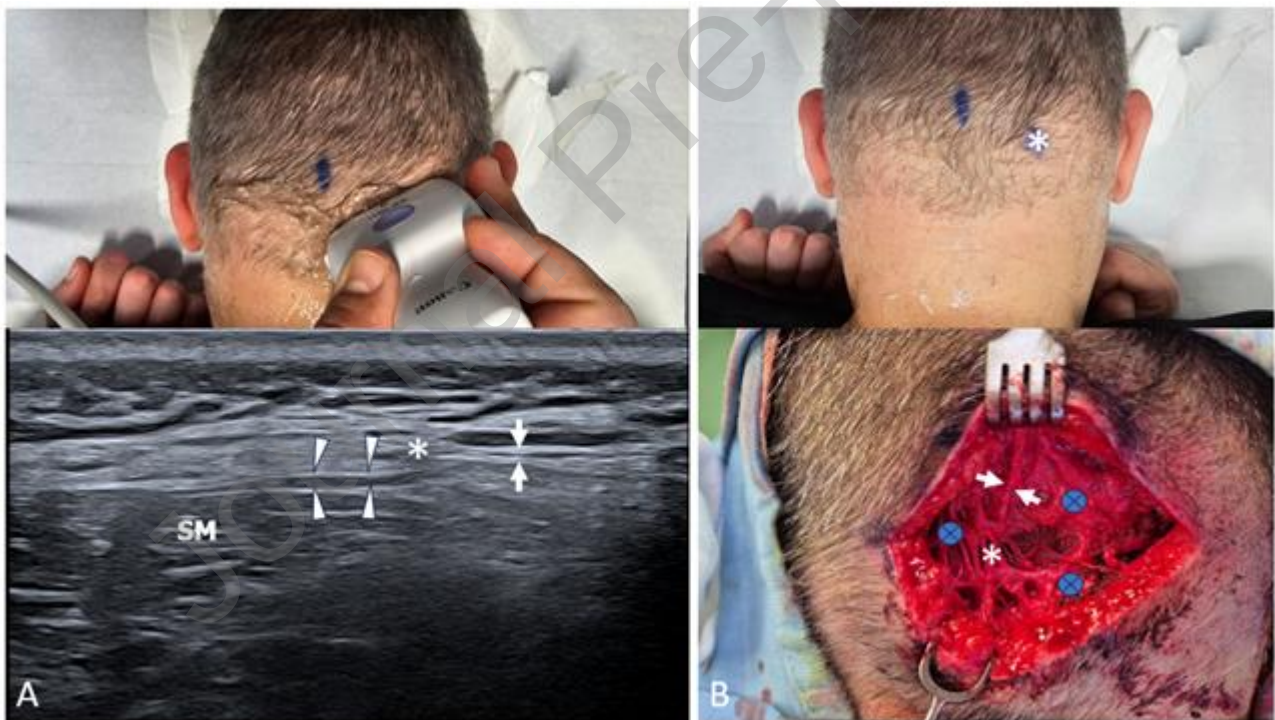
A: Ultrasound longitudinal view of the right GON (white arrowheads and arrows) between the trapezius aponeurosis and the semispinalis muscle (SM). Proximally to the crossing point (white asterisk), the nerve appears swollen (white arrowheads), while the artery does not appear enlarged. The compression causing the intraneural edema is likely related to the pressure exerted by the fascia. Distal to the crossing point, the nerve diameter
